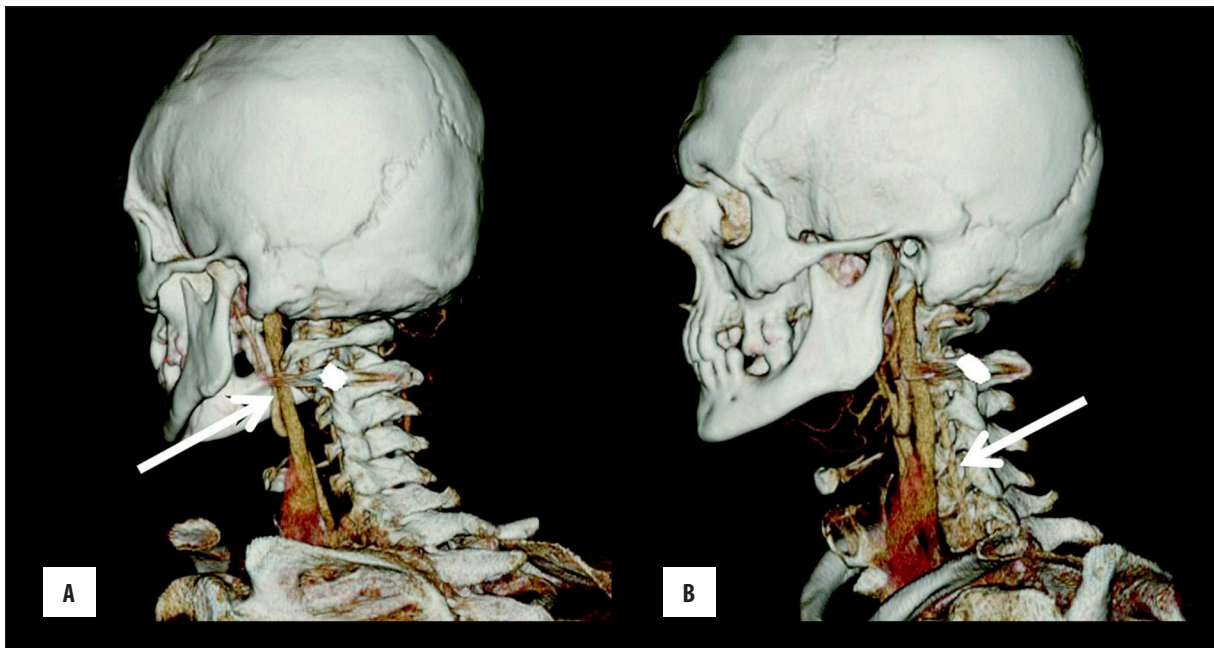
Intact left carotid artery (A, arrow) and intact left vertebral artery (B, arrow) on rotated 3D CT reformations to analyze the bullet path and the vessel anatomy.
